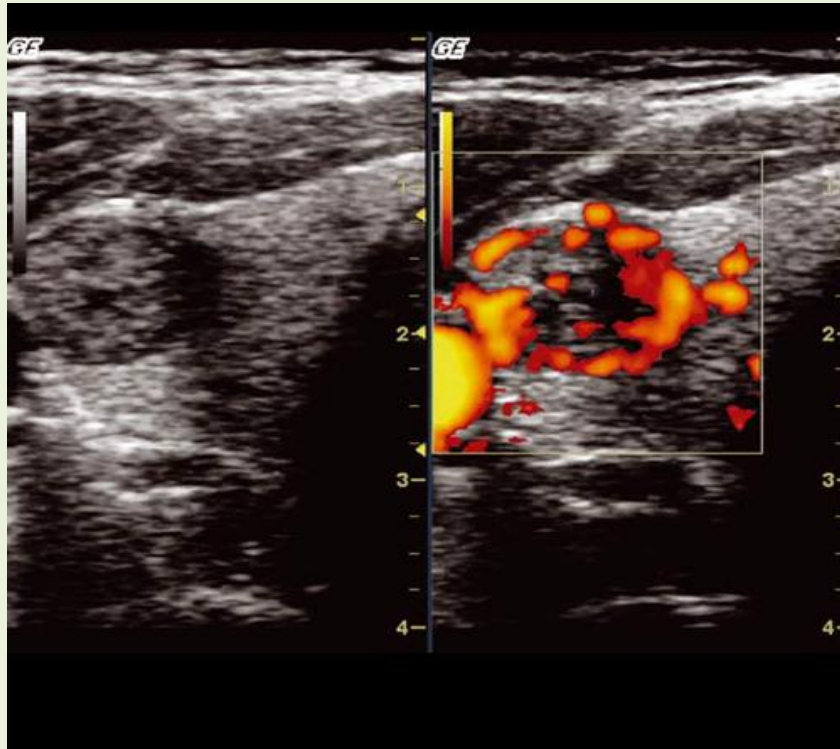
Figure showing hypo echoic nodule as seen in ultrasound
